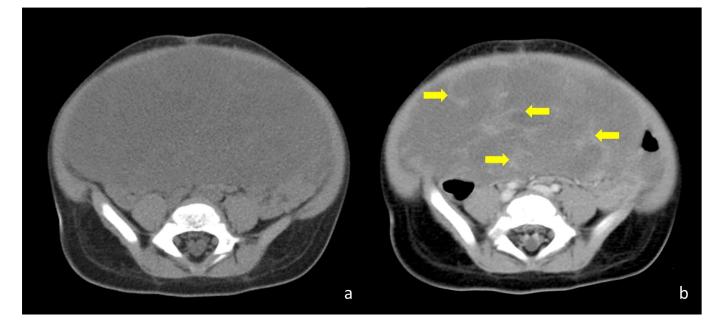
Two year old boy with mesenchymal hamartoma of the liver. Low dose CT, performed with a GE Light Speed Plus (4 slice-CT). Injection of 28ml (2ml/Kg) of 300mg/ml iodine concentration non-ionic contrast agent. Non-enhanced (a) and contrast-enhanced (b) 2,5mm thickness reconstruction images in similar axial planes demonstrate a large mass extending through the lower quadrants of the abdomen. In this plane, it is predominantly cystic, containing multiple enhancing septa (arrows).
